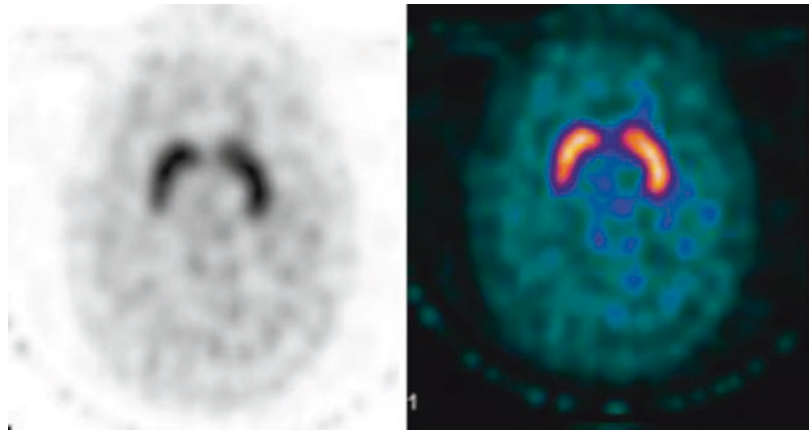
Abnormal ^{123}I -FP-CIT SPECT: transaxial SPECT of a 60-year-old male with Parkinson's disease. In both the left and right hemispheres, there is loss of uptake in the posterior putamen. In addition, the right hemisphere
